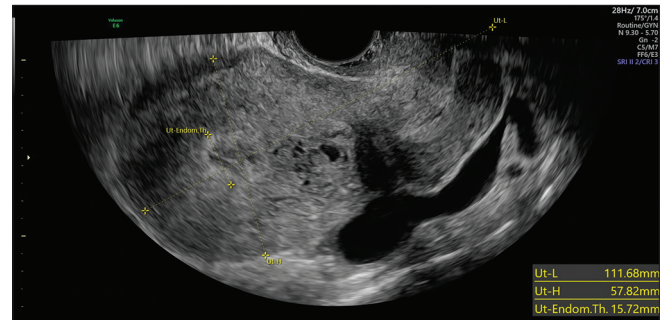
Grayscale bidimensional sonogram showing longitudinal view of uterine body with an inhomogeneous endometrium with multiple anechoic spaces. A free fluid of the cul the sac of Douglas is also visualized
